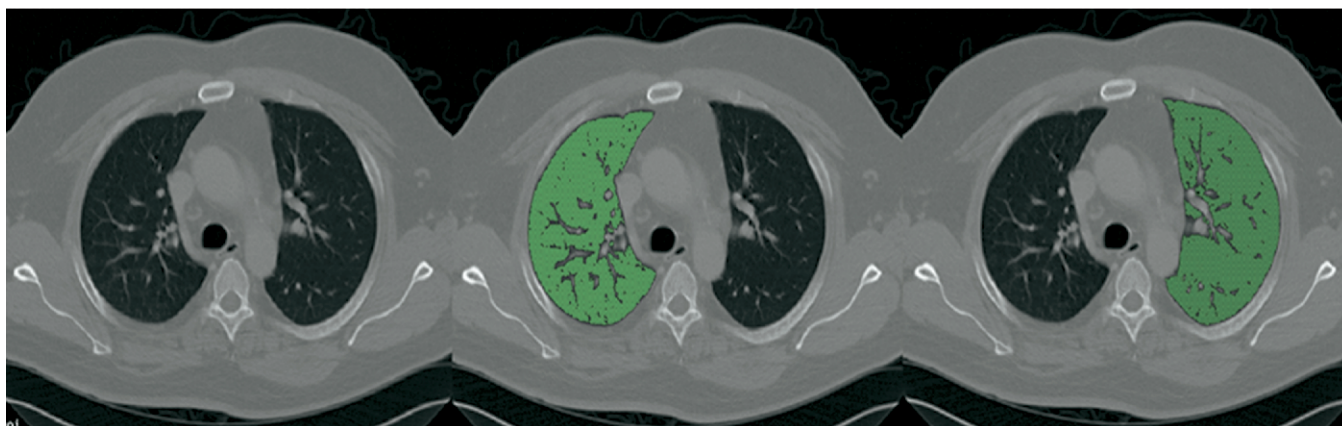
Axial CT image through lungs shows computer-assisted segmentation of right and left lungs.
